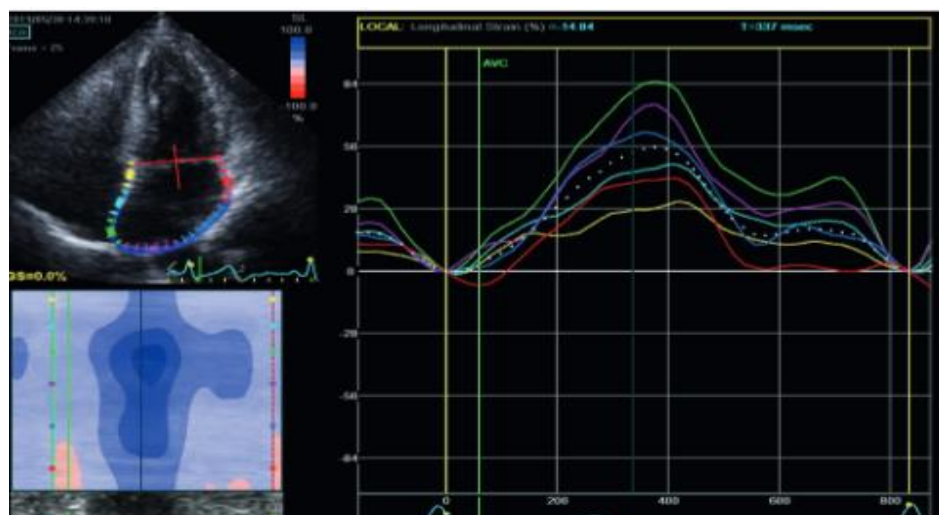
LA strain analysis by Speckle tracking echocardiography in patient diagnosed with cryptogenic stroke
